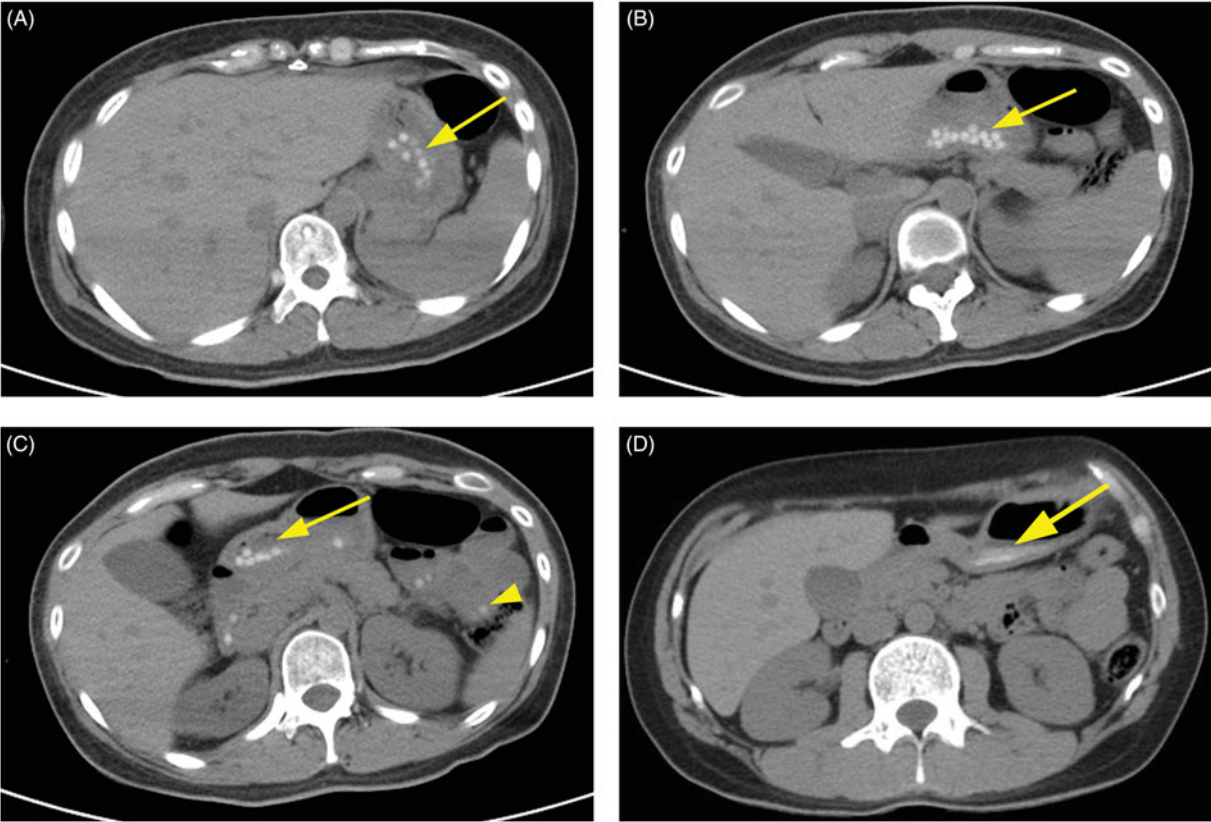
Typical computed tomography findings indicating presence of drug or positive radiodense image without drug appearance in the stomach lumen. (A–C) Arrows indicate drugs remaining in the stomach. (C) Arrowhead indicates drugs in the small bowel. (D) Arrows indicate positive radiodense image without drug appearance remaining in the stomach.
